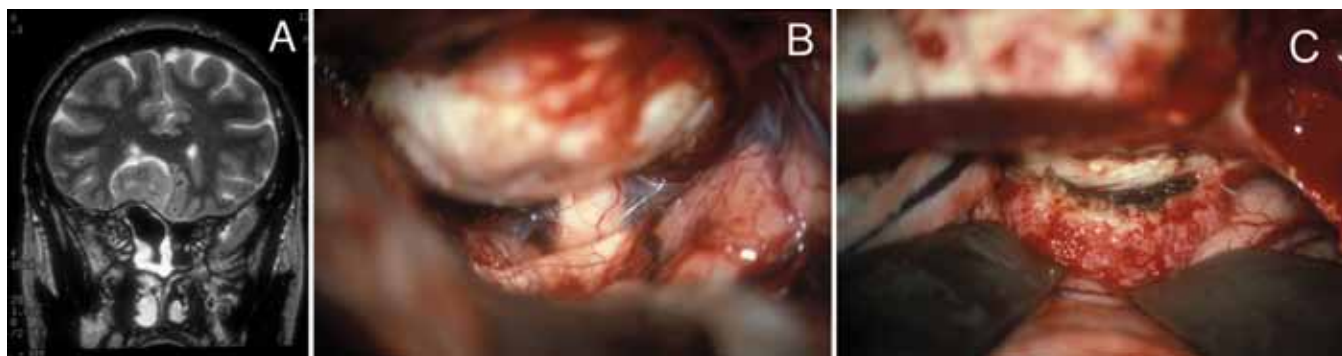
Case 3. A: Coronal T2-weighted MR image demonstrating an extraaxial mass associated with asymmetrical enlargement of the sphenoid sinus. The mass is heterogenous and somewhat hyperintense to surrounding brain. B: Intraoperative photograph showing two retractor blades elevating the right frontal lobe. The olfactory tract can be seen at the tip of the retractor blade. A thin veil of arachnoid is deeper, and behind that is the right optic nerve. The planum sphenoidale and right orbital roof appear at the top of the image, bowed upwards. C: Intraoperative photograph showing the meningioma, separated from the dura and exposing the underlying planum sphenoidale and right orbital roof with the frontal lobes retracted.
